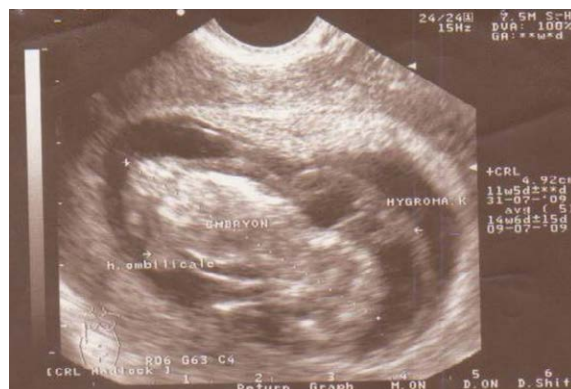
Obstetrical ultrasonography at 10 WP Enormous nuchal Cystic Hygroma.
